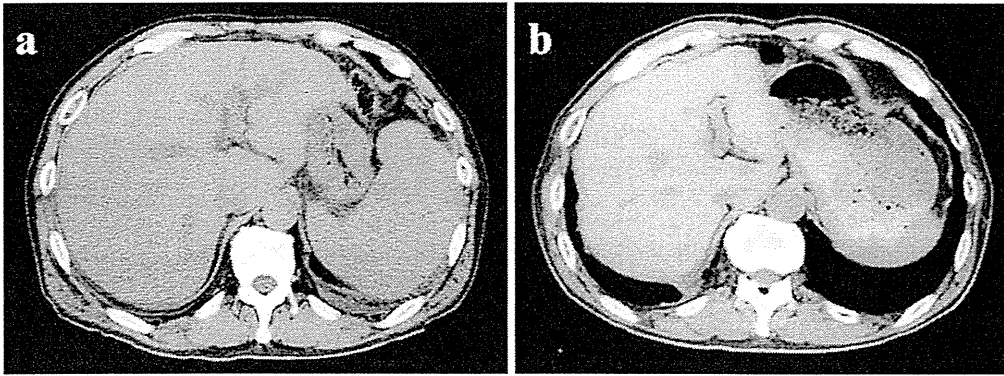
Computed tomography (CT) of the abdomen, transverse scan. (a) CT scan obtained at time of admission. (b) CT scan obtained five months before admission. The liver and spleen were enlarged on the last CT scan compared to that observed on the previous CT scan.
